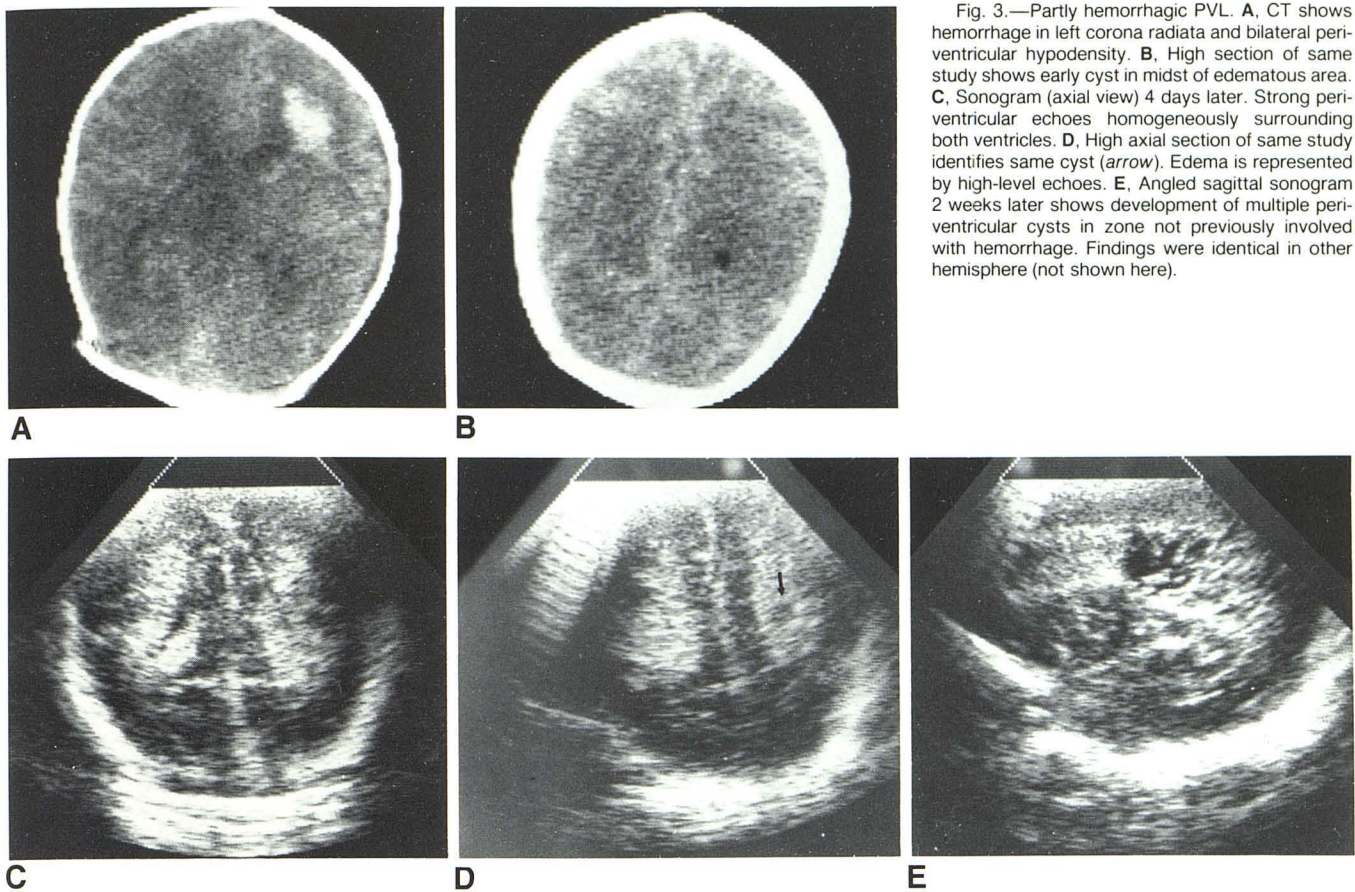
Partly hemorrhagic PVL. A, CT shows hemorrhage in left corona radiata and bilateral periventricular hypodensity. B, High section of same study shows early cyst in midst of edematous area. C, Sonogram (axial view) 4 days later. Strong periventricular echoes homogeneously surrounding both ventricles. D, High axial section of same study identifies same cyst (arrow). Edema is represented by high-level echoes. E, Angled sagittal sonogram 2 weeks later shows development of multiple periventricular cysts in zone not previously involved with hemorrhage. Findings were identical in other hemisphere (not shown here).
